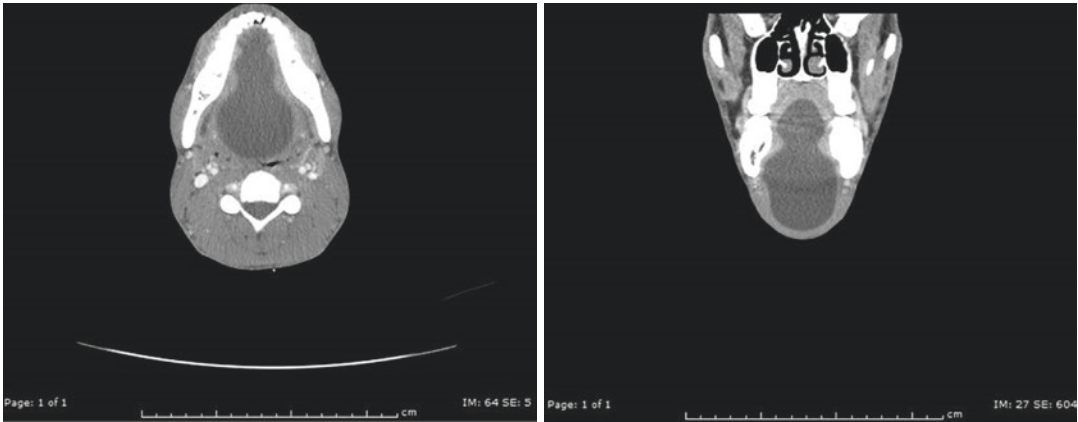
Axial and coronal CT view of a patient with plunging ranula
